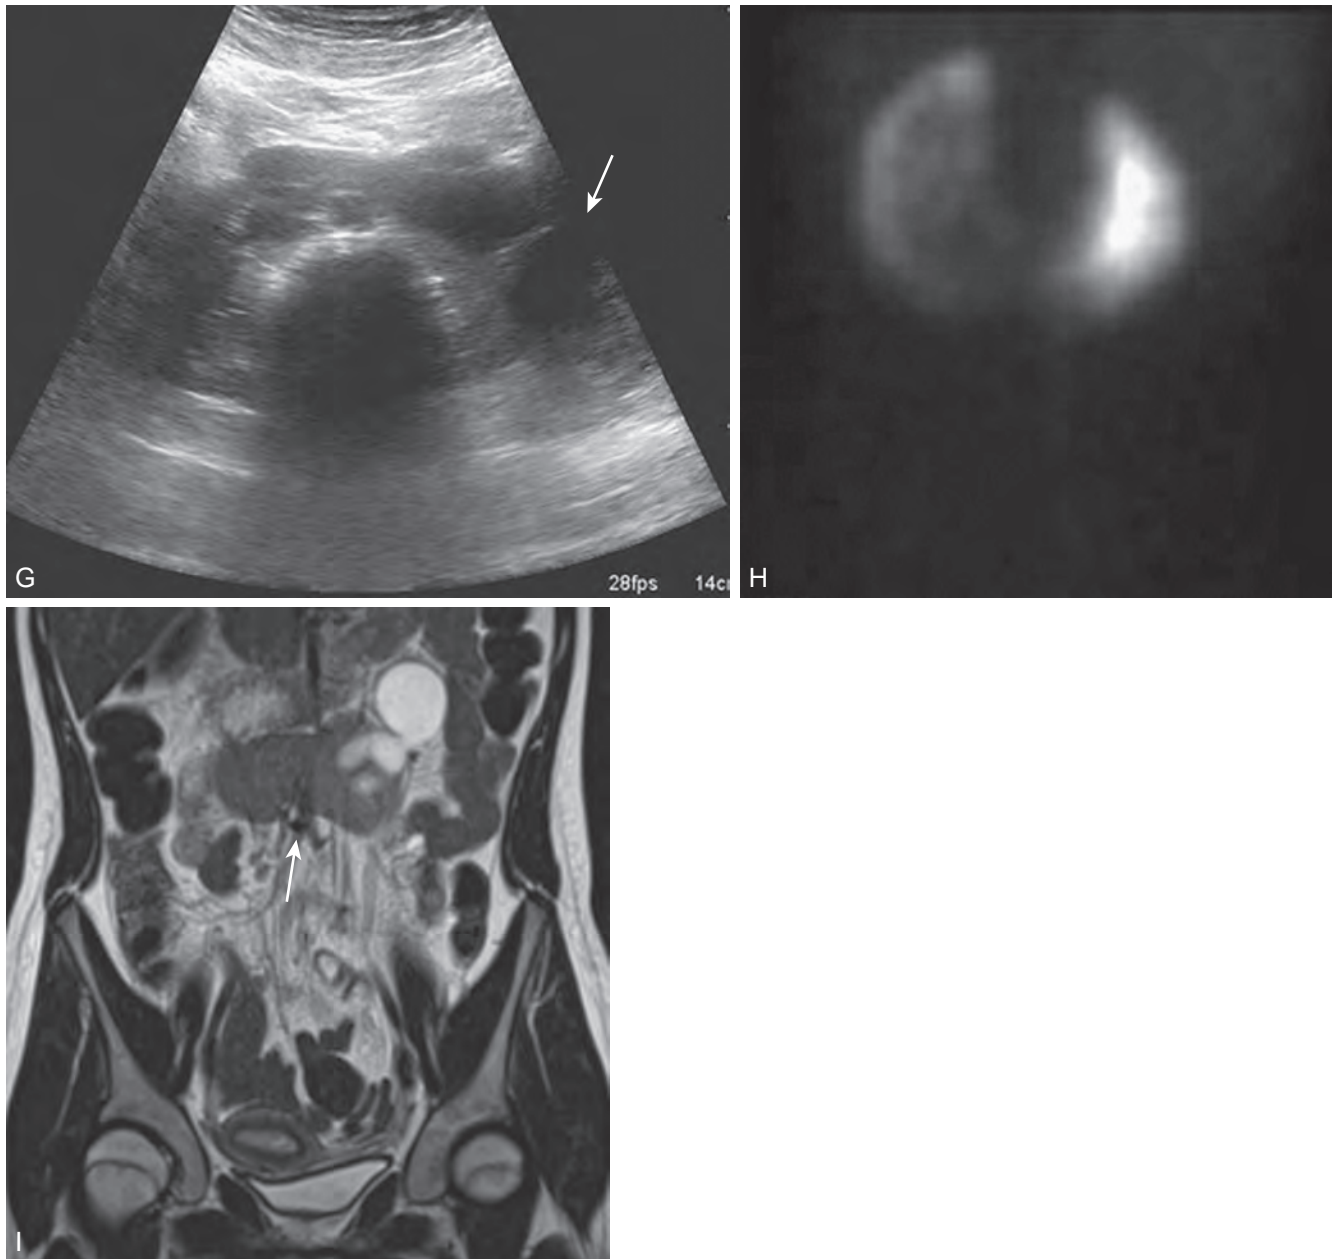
cont'd G, Transverse sonogram of 14-year-old girl with left flank pain found to have marked left hydronephrosis in a horseshoe kidney (*arrow*). H, MAG3 scan demonstrates left ureteropelvic junction obstruction. I, Coronal T2 images of MR urogram show the isthmus (*arrow*) and severe left hydronephrosis. (A, From Benjamin JA, Schullian DM. Observation on fused kidneys with horseshoe configuration: the contribution of Leonardo Botallo [1564]. *J Hist Med Allied Sci* 1950;5:315–26, after Gutierrez, 1931; B, from Weiss, MA, Mills, SE. *Atlas of genitourinary tract disorders*. Philadelphia: JB Lippincott; 1988.)
